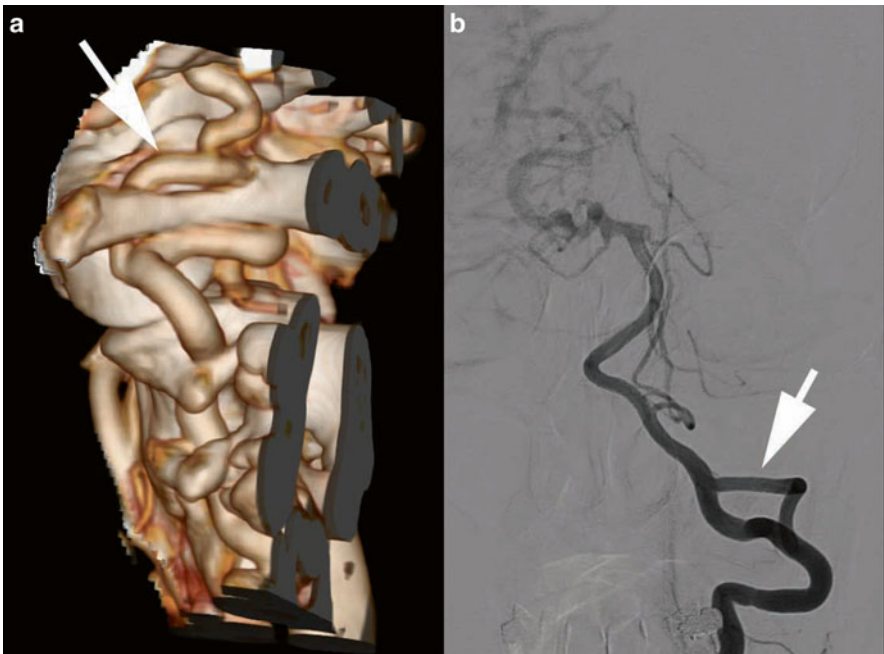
Fifty-six y/o female presented with a large arteriovenous malformation (AVM) of the brain. A CTA was followed by DSA for evaluation of the AVM. VR-CTA (a) depicts the duplication of the left vertebral artery (white arrows) at the craniocervical region, which is easier depicted at DSA (b) because of bone subtraction
